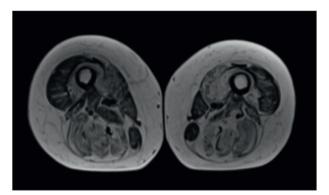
Muscle MRI. Muscle MRI of lower limbs showed a severe involvement of adductors longus, magno and brevis (Score 4), glutei and tight posterior muscles (Score 3).
